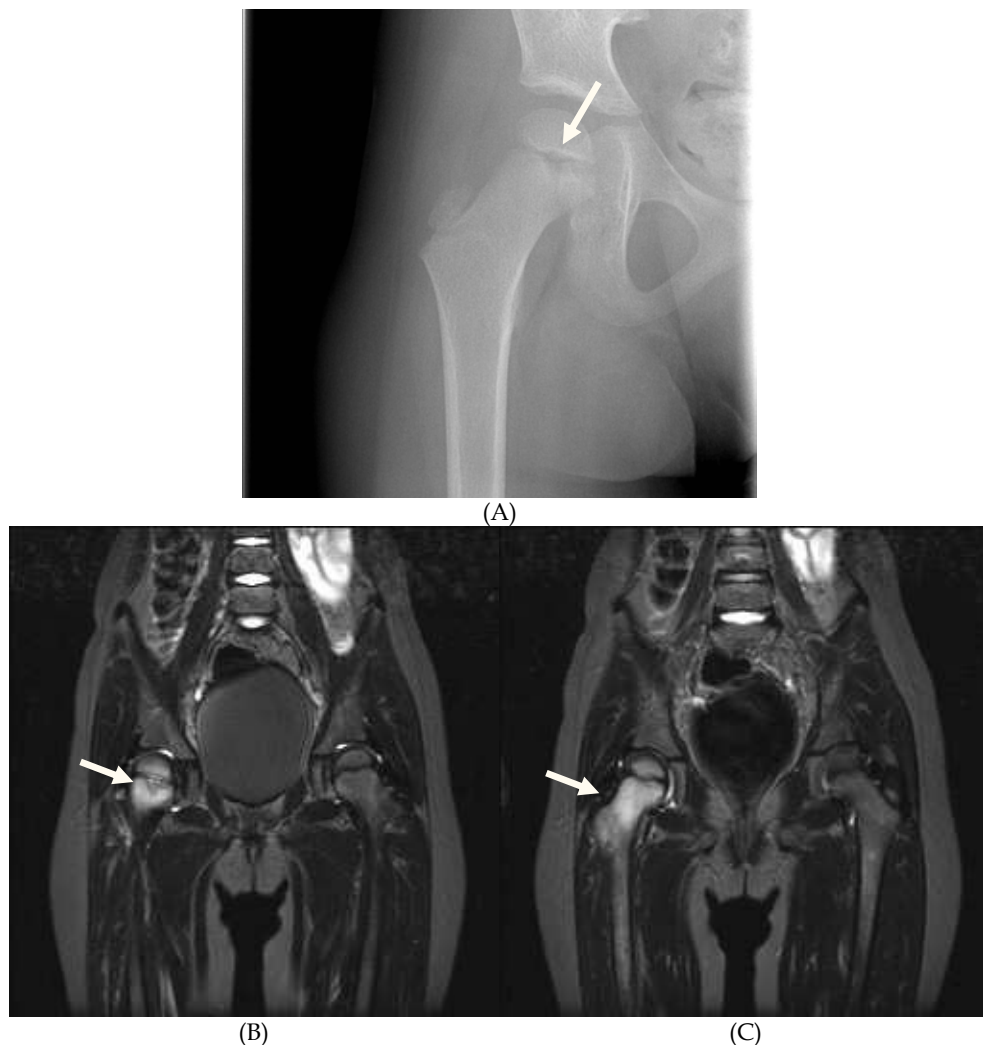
Images of a 4.5-year old girl at CRMO diagnosis. (A). Pre treatment right femoral radiograph: only subtle radiolucency is seen at the femoral metaphysis (arrow) despite severe hip pain. (B). Short-tau inversion-recovery (STIR) images of MRI performed at the same day confirms the focal lesion adjacent to the growth plate (B), but also shows extensive bone marrow edema in the proximal femur (C) (arrows).
